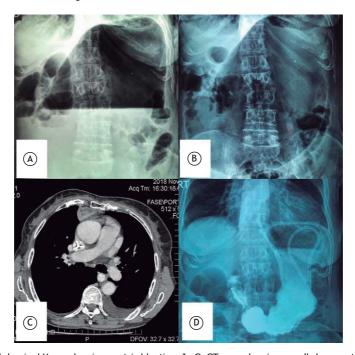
In A and B, abdominal X-ray showing gastric bloating. In C, CT scan showing a well-demarcated anterior mediastinal tumor. In D, gastrography showing normal gastric emptying.
